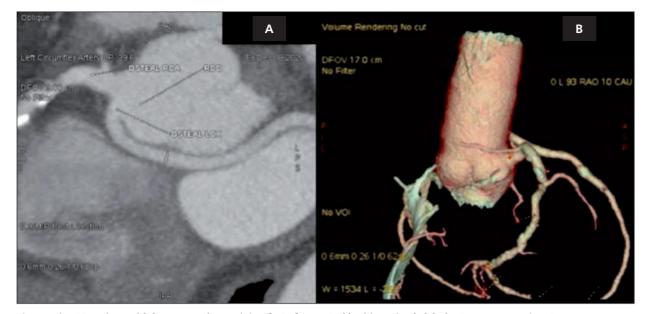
The CCTA showed (A) an anomalous origin of LCx from RCC (double ostium). (B) The 3D reconstruction CT.
